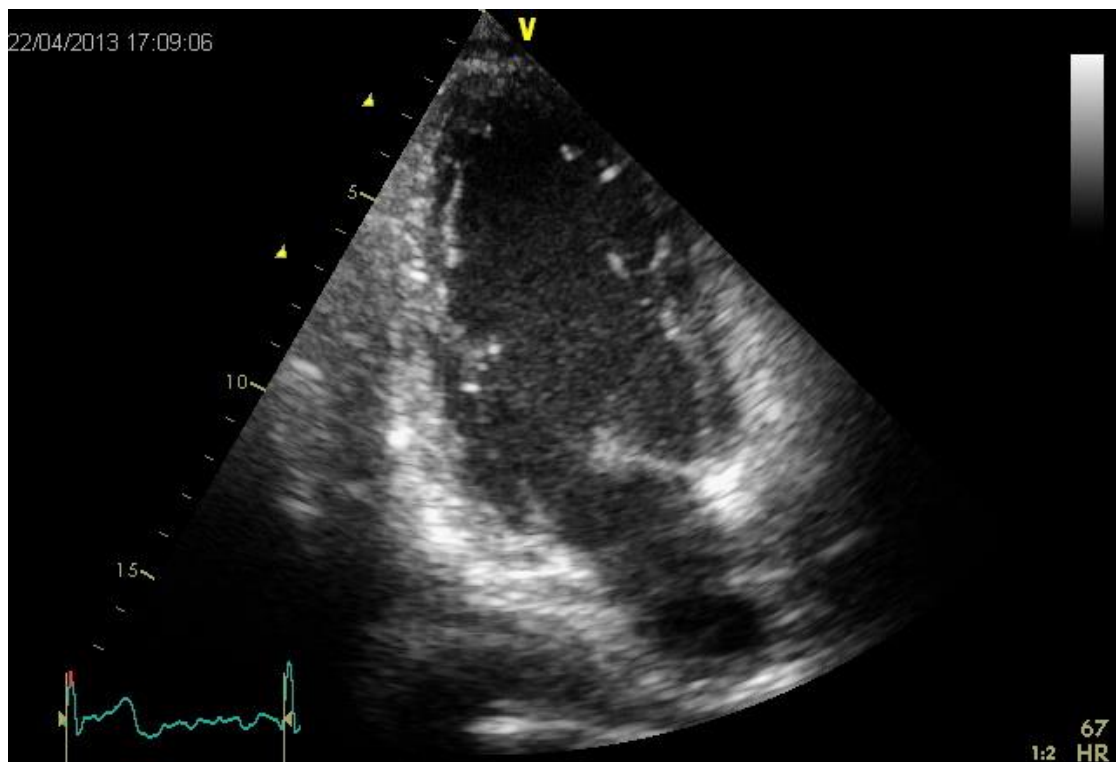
Apical Two Chamber View
